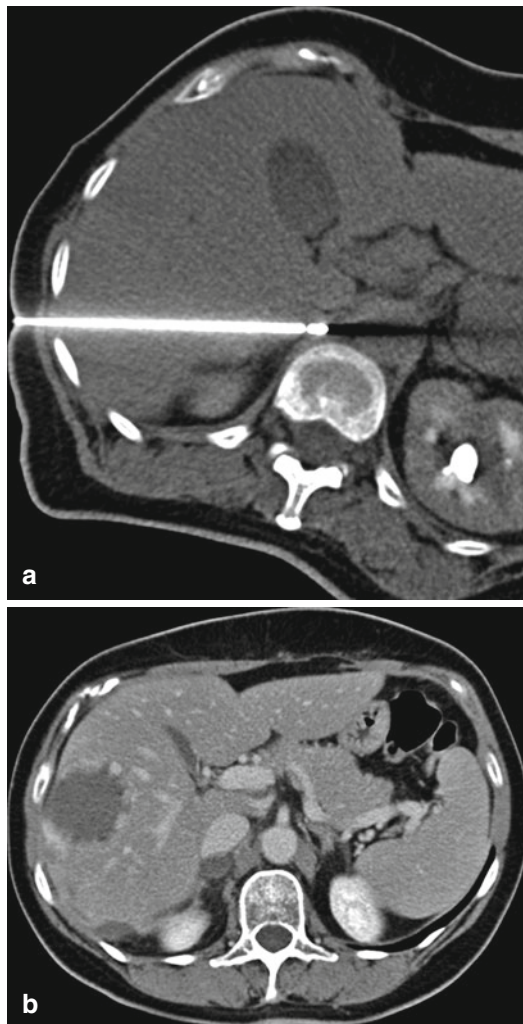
A 56-year-old woman suffering from metastatic melanoma with a history of locally controlled liver and lung metastases. In order to reduce the total tumor burden, the right adrenal gland was treated by RF ablation. Ablation was performed under CT guidance via a transhepatic approach (a). The contrast-enhanced post-procedural CT scan shows the lack of contrast enhancement as indicator of successful treatment. CT also depicts a liver hemangioma (b)
